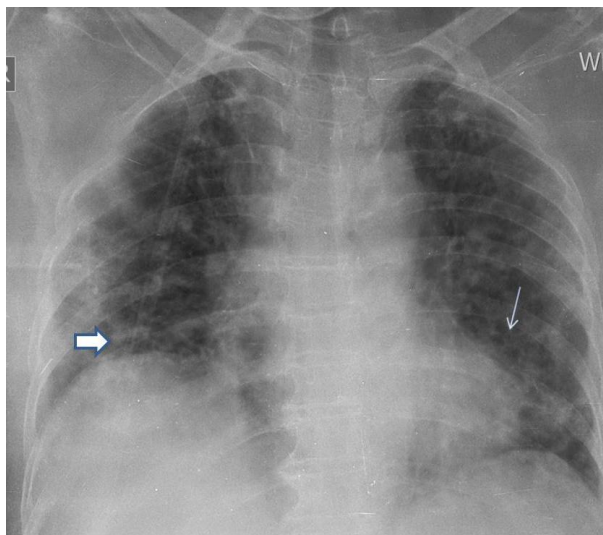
AP chest radiograph reveals patchy areas of consolidations (arrows) in predominantly central distribution
